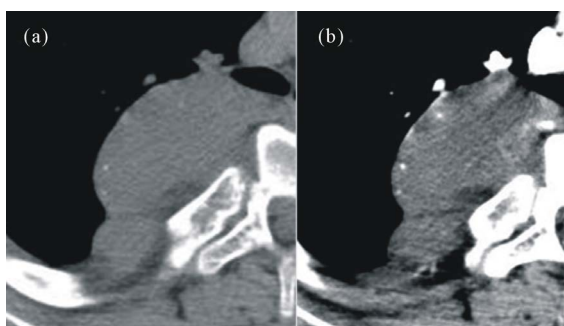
A 16-year-old woman with a ganglioneuroma in the right para-vertebral space (case 3). Axial (a) non-contrast CT shows a well-demarcated 50 HU mass with a band-like shape, fat-attenuation component and a punctate calcification. Axial (b) contrast enhanced CT shows no obvious enhancement (46 HU) on delayed phase scanned with a delay time of 100 sec after administrating contrast material. Axial (c) T1-weighted MR image (T1WI) shows a mass with a low signal-intensity similar to that of adjacent muscles. Axial (d) Post-contrast T1 weighted MR image with Gd-DTPA shows a heterogeneous high enhancement. The degree of contrast enhancement on MRI is more apparent than that on CT. The scores of each vessel are as follows; LA: 1, LV: 0, SA: 6, SV: 38, and CV: 34.
